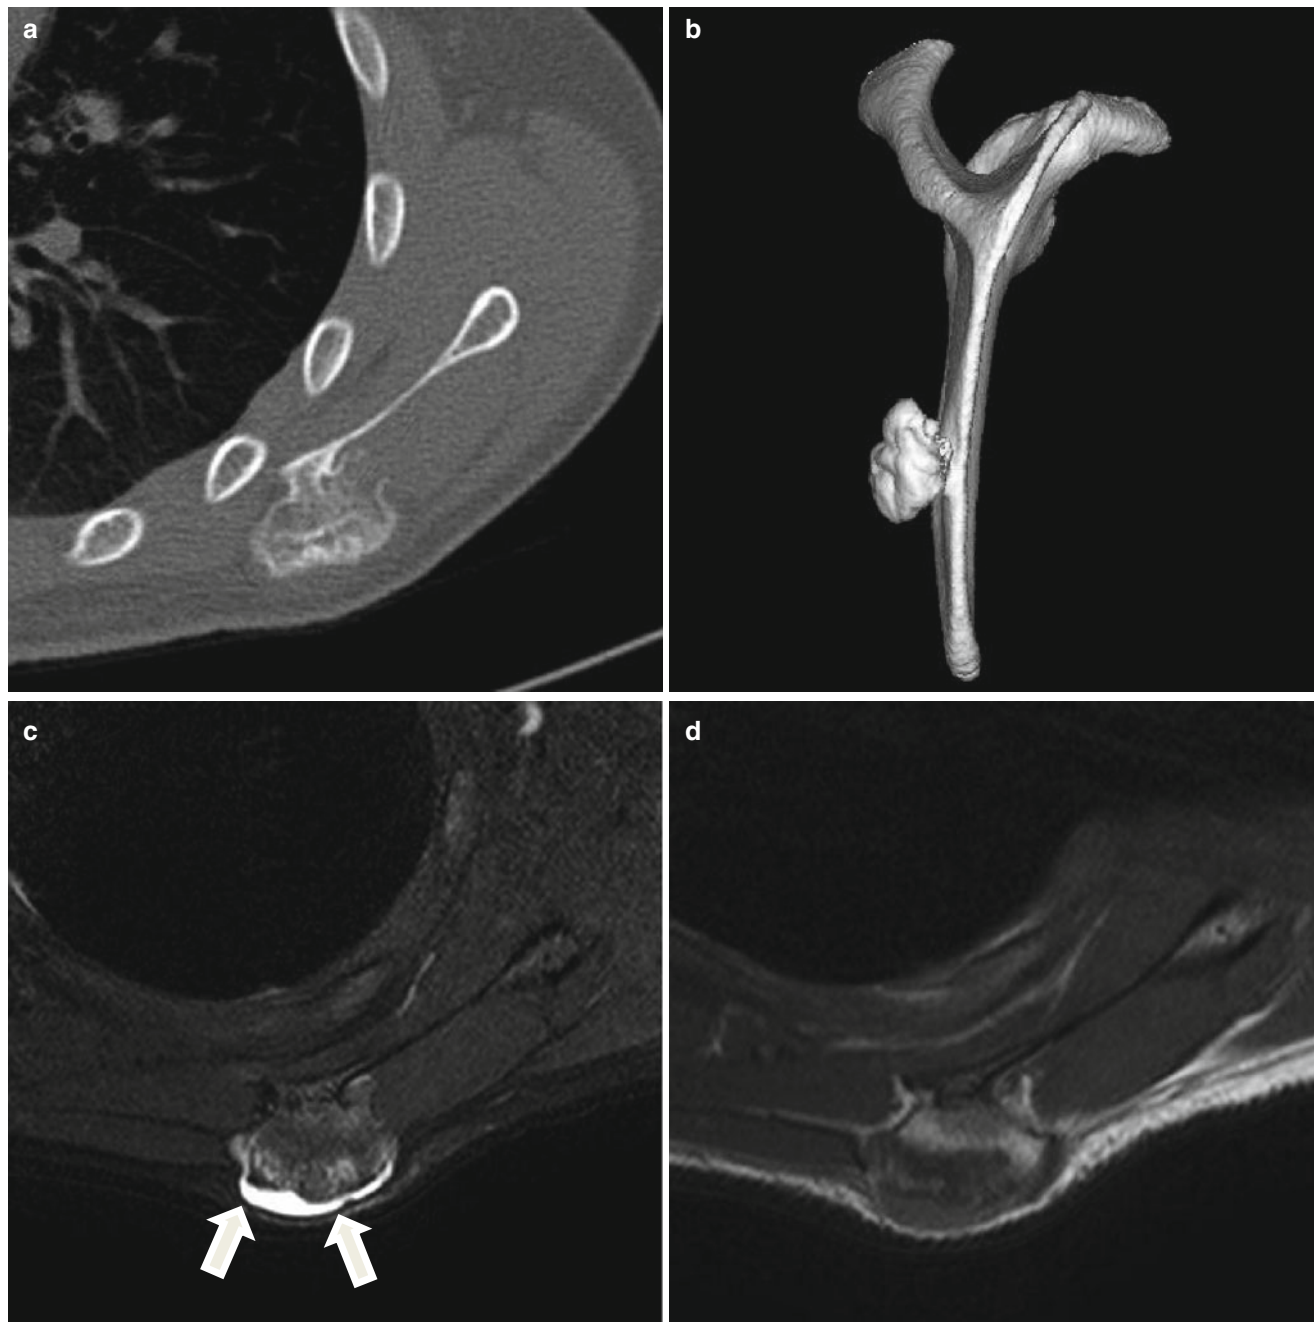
Osteochondroma in the left scapula. (a) Axial CT image shows a protruding bone-forming mass arising from the left inferomedial scapula of which the medullary cavity is continuous with the mass. (b) 3D reconstruction image of the scapula clearly demonstrates
